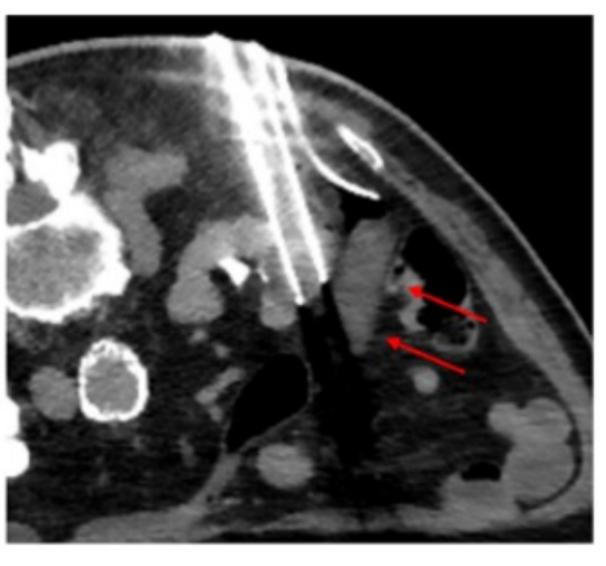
Intraprocedural CT demonstrates two cryoprobes advanced into the target tumor with the balloon (arrows) displacing the adjacent bowel away from the ablation zone.
